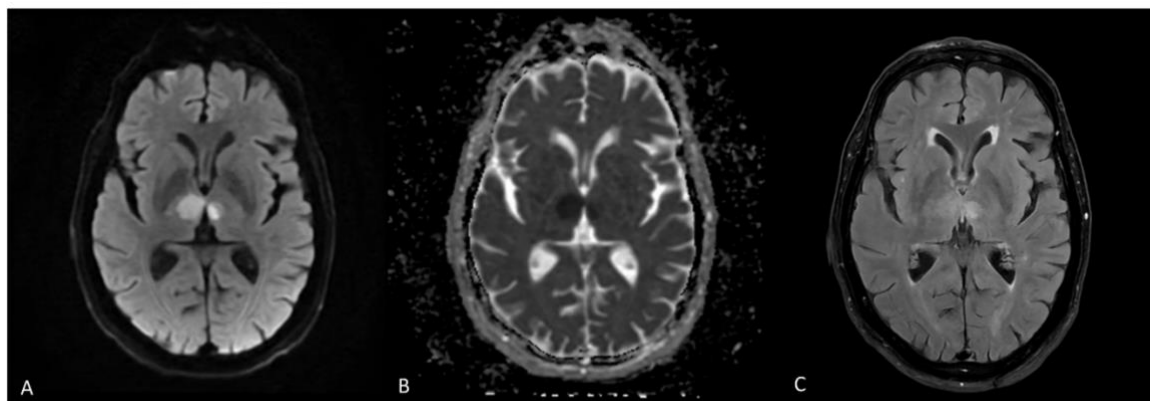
MRI findings at the level of the thalami
